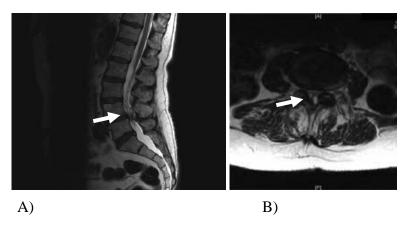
MR images T2 –weighted sequences of lumbar spine showing the stenotic segment at the L4/5 level (white arrow): A) Sagittal view; B) Axial view.
